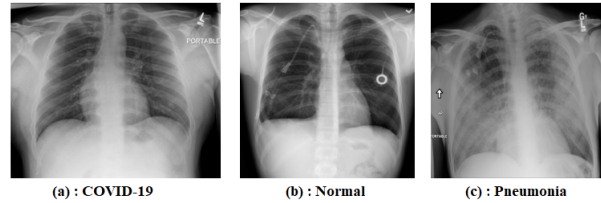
Example of chest radiograph samples from the COVIDx dataset.
